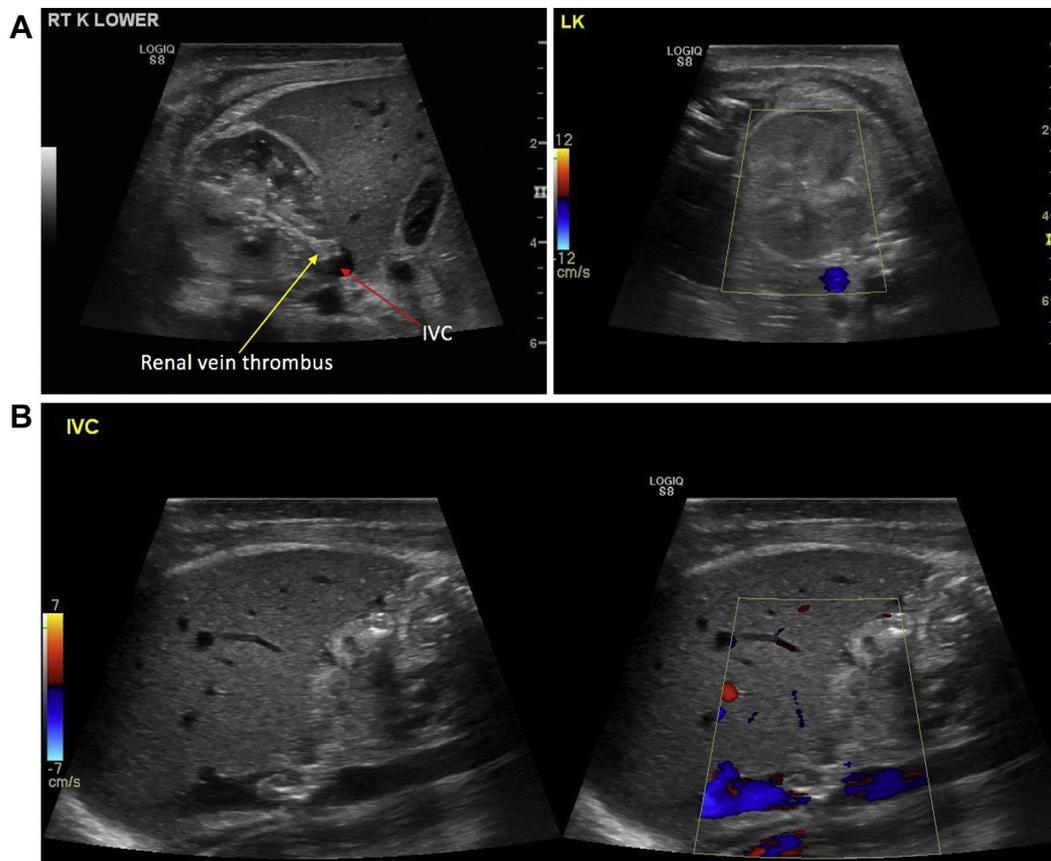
(A) Right and left kidneys demonstrating reduced corticomedullary differentiation and increased cortical echogenicity. The right kidney showed thrombus extension from the inferior vena cava (IVC) into the right renal vein, and the left kidney showed absence of colour Doppler flow and increased linear echogenicities, suggesting thrombi within the smaller renal veins. (B) Ultrasound image with and without Doppler of the inferior vena cava demonstrating a partially occlusive thrombus.
